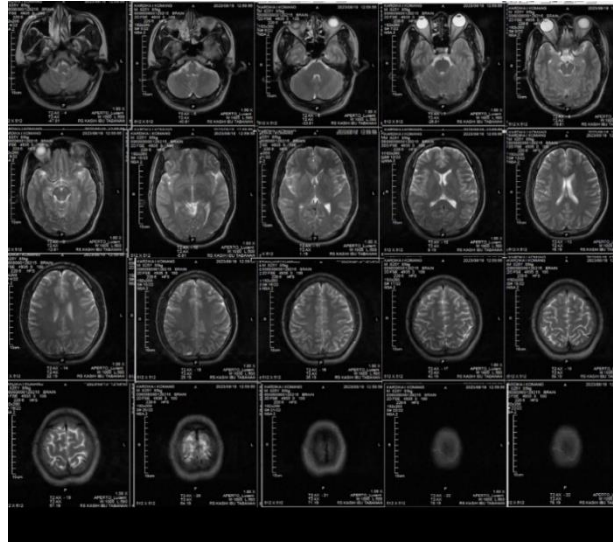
Head MRI Post Treatment
